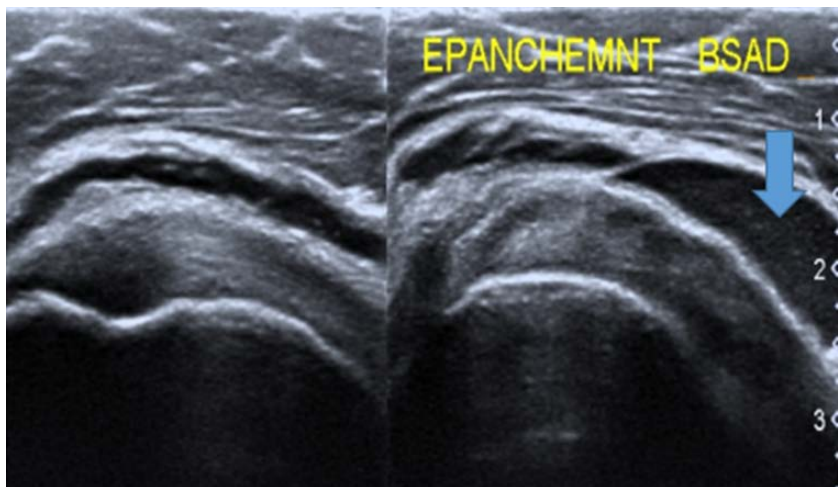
A 20-year-old patient in a road traffic accident. Trauma to the right shoulder. Swelling with pain on mobilization of the right shoulder. Ultrasound at 5 days. High-frequency probe, longitudinal section. Echogenic fluid effusion in the left subacromial-deltoid bursa (blue arrow). Source: CHUYO IMR Department.
